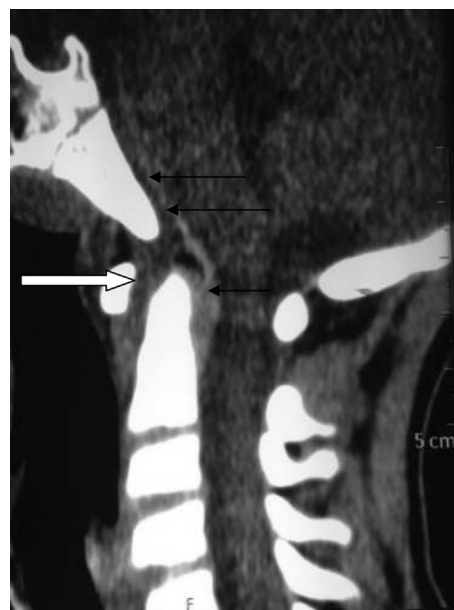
CT CV junction and cervical spine (after seven days of injury) showing atlantoaxial dislocation (white arrow) and shows well defined hyperdensity noted posterior to dens of c2 vertebrae extending superiorly posterior to clivus suggestive of epidural hemorrhage (black arrows).
